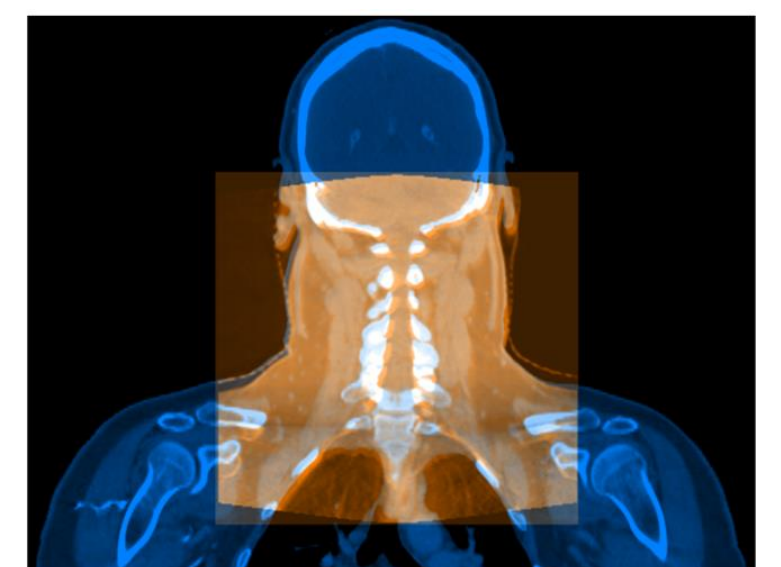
Image showing the CBCT FOV (orange) overlaid on the pCT (blue) showing why the pathway is not used for patients with involvement in nodal regions.
